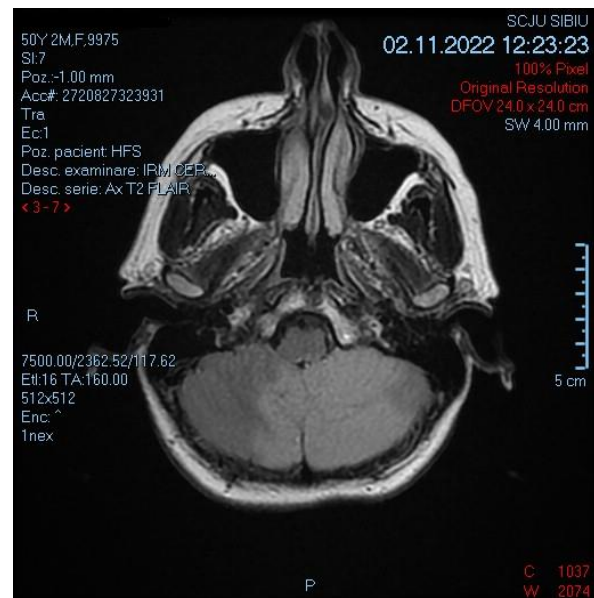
MRI Head performed on 02.11.2022.
